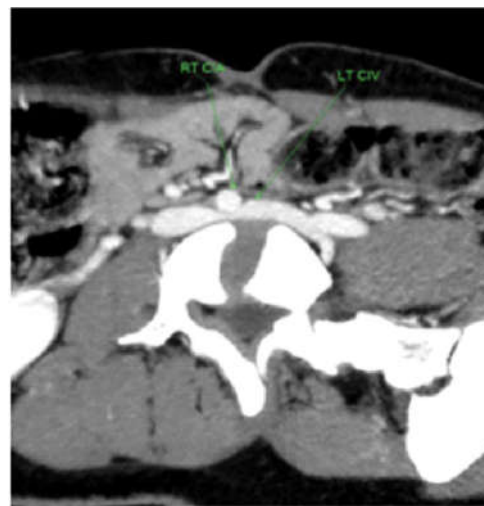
CT Peripheral Angiogram.
